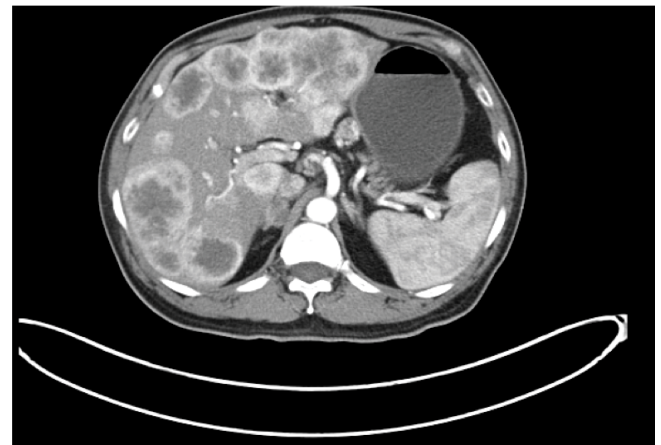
The CT scan revealed the presence of antral gastric mass along with multiple extensive metastases to the liver, lung and retroperitoneal lymph nodes.
